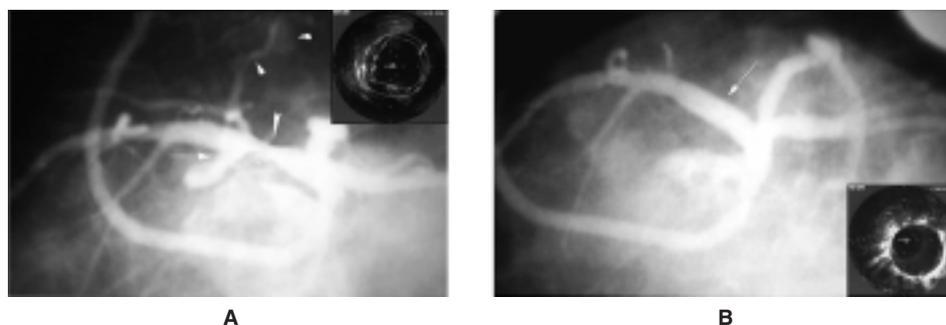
Left lateral projection (A) of the left coronary artery of a 47-year-old man who presented with early post-myocardial infarction angina. A stenosis in the proximal segment of the left anterior descending coronary artery is evident (white large triangle) and quantified as occupying 40% of the vessel lumen by intracoronary ultrasound examination (small panel). The fistula origin (arrow) with small branches emerging from it (small triangles) is shown. Control angiography after ePTFE covered stent deployment in the 90° left lateral and 30° caudal projections (B) shows complete occlusion of the fistula and lack of residual stenosis in the left anterior descending coronary artery. Full expansion of the stent graft was confirmed by intracoronary ultrasound (small panel). From Balanescu et al.⁶⁷, with permission.
